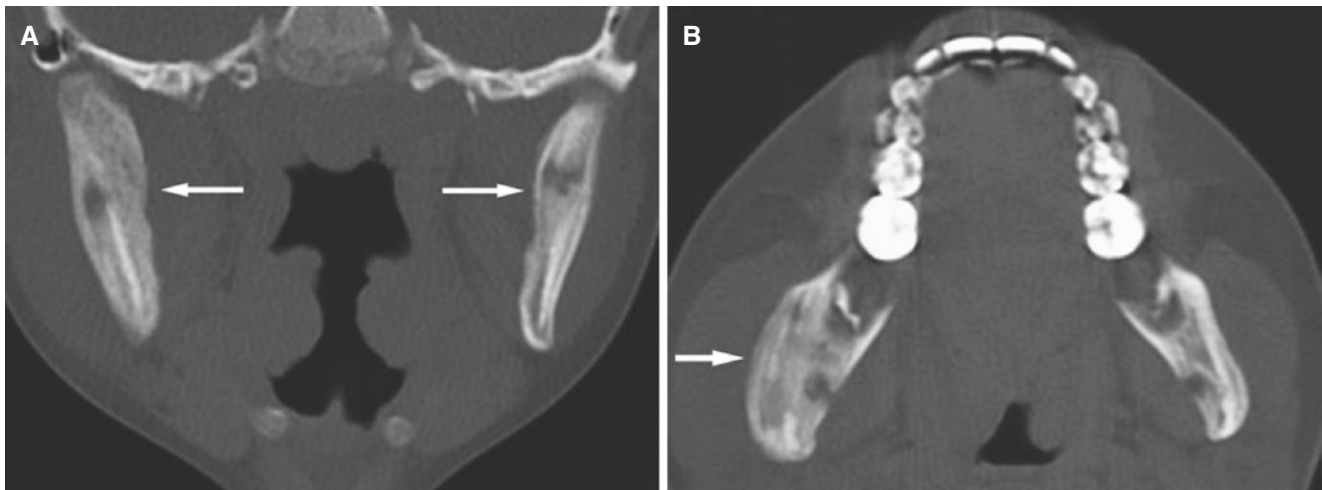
Osteomyelitis with bilateral periostitis, mandible; 11-year-old female with variable pain and mouth-opening capacity for about 6 months, believed to be caused by juvenile arthritis. (A) Coronal CT
